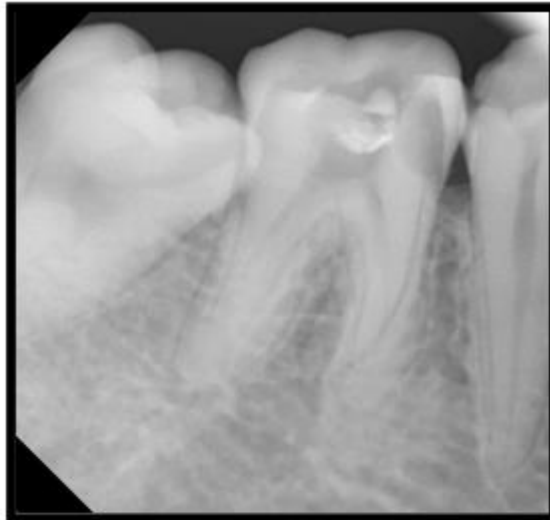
Pre-operative radiograph of #46
